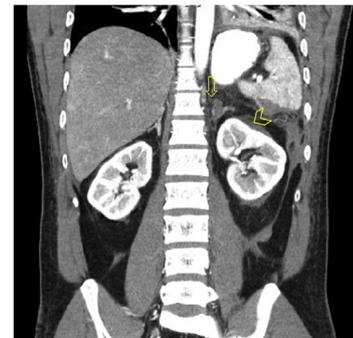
Coronal contrast enhanced CT scan of the abdomen showing irregular 2 × 2.5 cm hematoma in the left adrenal gland (arrow). There is also subcapsular hematoma in the left kidney (arrow head) and retroperitoneal bleeding with thickening of the left Gerota's fascia.
